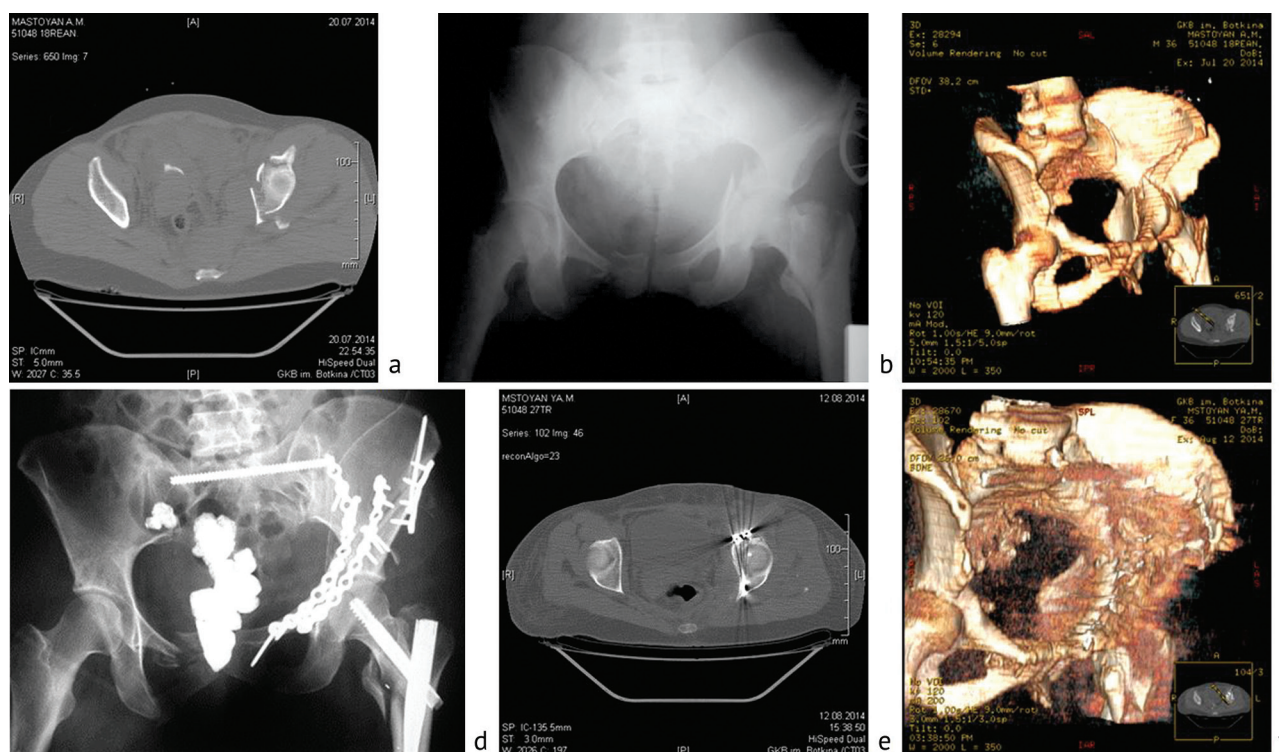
Clinical instance: (a) CT scan of the injury in the anterior and posterior projections showing displaced fracture of both columns on the left, displaced fracture of the QLP; displaced fracture of both pubic and ischial bones on the right, a fracture of the lateral mass of the sacrum on the left; comminuted displaced fracture of the left iliac wing; (b) radiograph of the pelvis, displaced fracture of the QLP; (c) 3D reconstruction of fractured anterior column, a fracture of the QLP with transition to the anterior column and pubic bone; (d) AP and lateral view after ORIF of both columns and the iliac wing with reconstruction plates, fixation of the broken proximal femur with PFN and of the sacrum with a long cannulated screw; (e) axial CT scan of the pelvis after ORIF with fixation of both columns with reconstruction plates; (f) 3D reconstruction of the pelvis after ORIF of both columns using reconstruction plates
